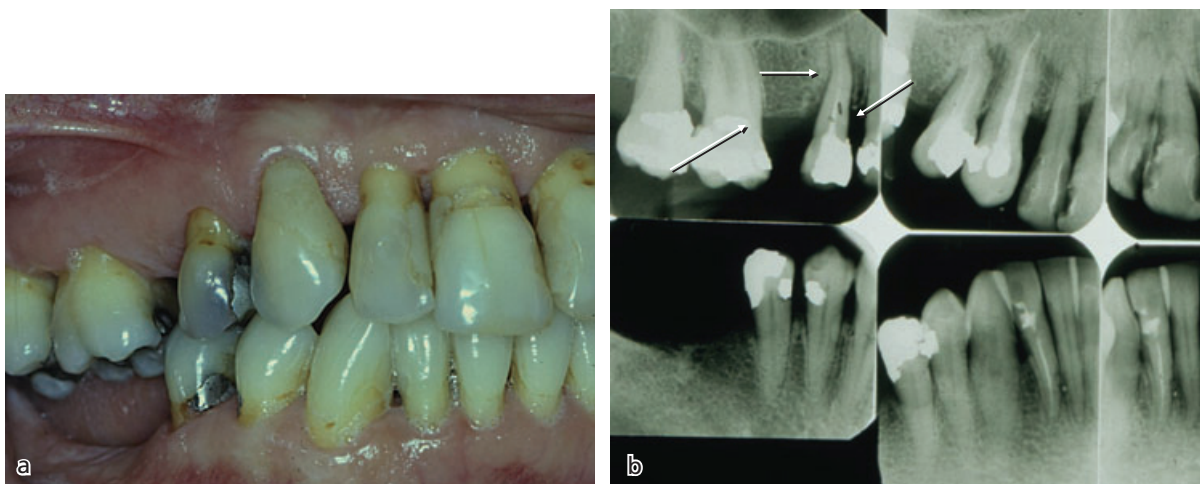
(a) The clinical condition in quadrants 1 and 3 of a subject with chronic periodontitis. Most teeth in both quadrants exhibit advanced recession of the soft tissue margin. (b) Corresponding radiographs: the mesial surface of tooth 16 (arrow) has a normal periodontal tissue support, while the neighboring tooth, tooth 14, has lost several millimeters of bone support on the distal aspect (arrow). The mesial surface of tooth 14 has a comparatively normal tissue support (arrow).
